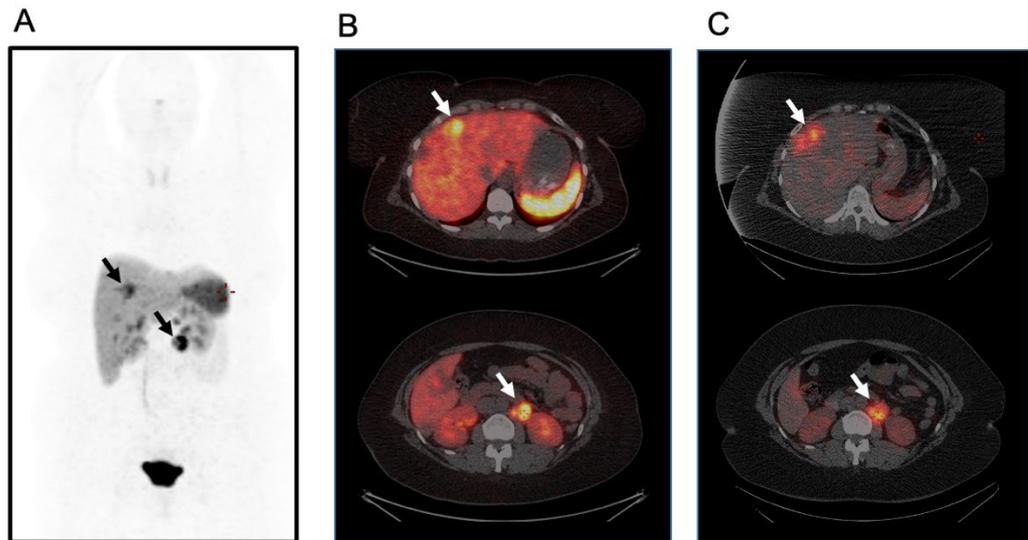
Maximum intensity projection (A) and fused PET/CT images (B) from a PET CT study using [^{68}Ga]Ga-DOTA-TATE in a patient with pancreatic insulinoma with liver and abdominal lymph node metastases (arrows). All lesions are identified in the PET study which allows characterization of the biological properties of the disease and identifies the patient as a candidate for somatostatin receptor targeted radionuclide therapy. C: Fused SPECT/CT images of the same patient 4 days following the first cycle of treatment with [^{177}Lu]Lu-DOTA-TATE. There is a high level uptake within the tumors previously identified with PET. The treatment resulted in long-term symptom control (dramatic reduction of the number of episodes of hypoglycemia caused by high insulin secretion from the tumors) and objective response on anatomical imaging following 4 cycles of treatment.
